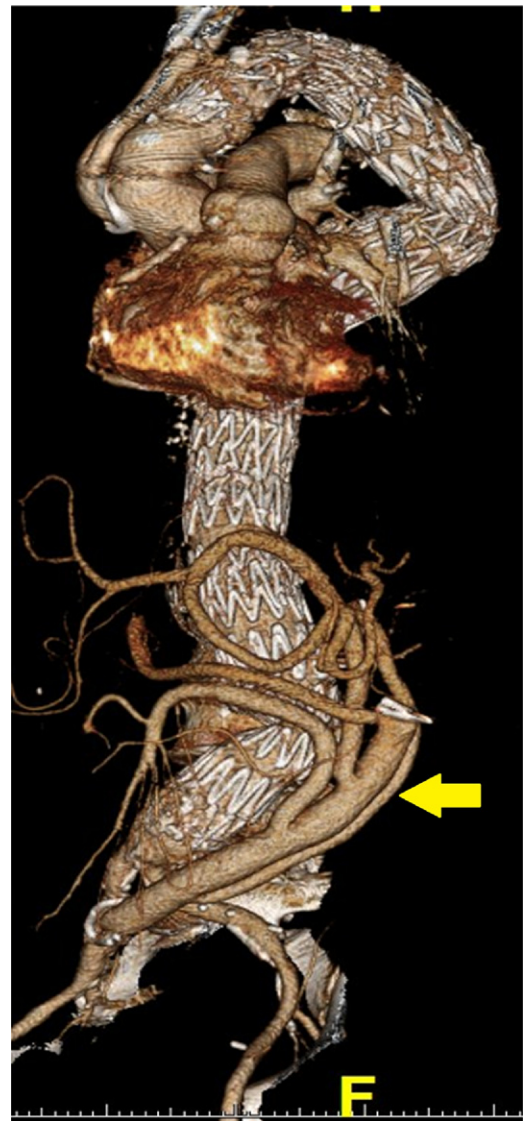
Three-dimensional reconstruction computed tomography angiography 1 year after stage II repair demonstrating intact repair with aneurysm exclusion, no endoleak, and patent grafts (*arrow*).
